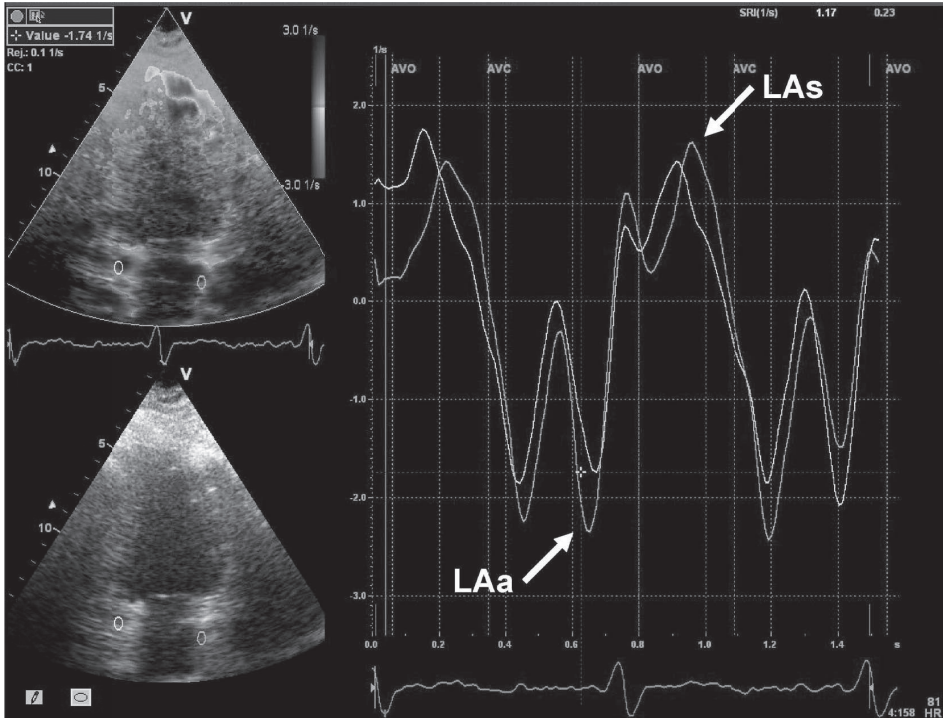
Strain rate imaging in the apical 2-chamber view in a patient at baseline. Samples are placed in the basal-mid atrial inferior (yellow) and anterior (green) atrial walls. With the use of the vertical green lines indicating aortic valve opening (AVO) and aortic valve closure (AVC), peak strain rate values of the different segments can be obtained (white arrows). LAa indicates peak LA strain rate during late ventricular diastole, representing the speed at which LA deformation during active contraction occurs. LAs indicates peak LA strain rate during ventricular systole, representing the speed at which LA deformation during LA expansion occurs.
